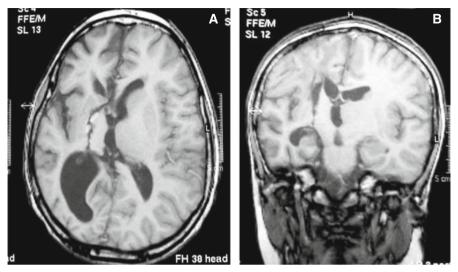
Hemispherotomy, post-operative MRI scan (A, axial view; B, coronal view) in a case of Rasmussen encephalitis
